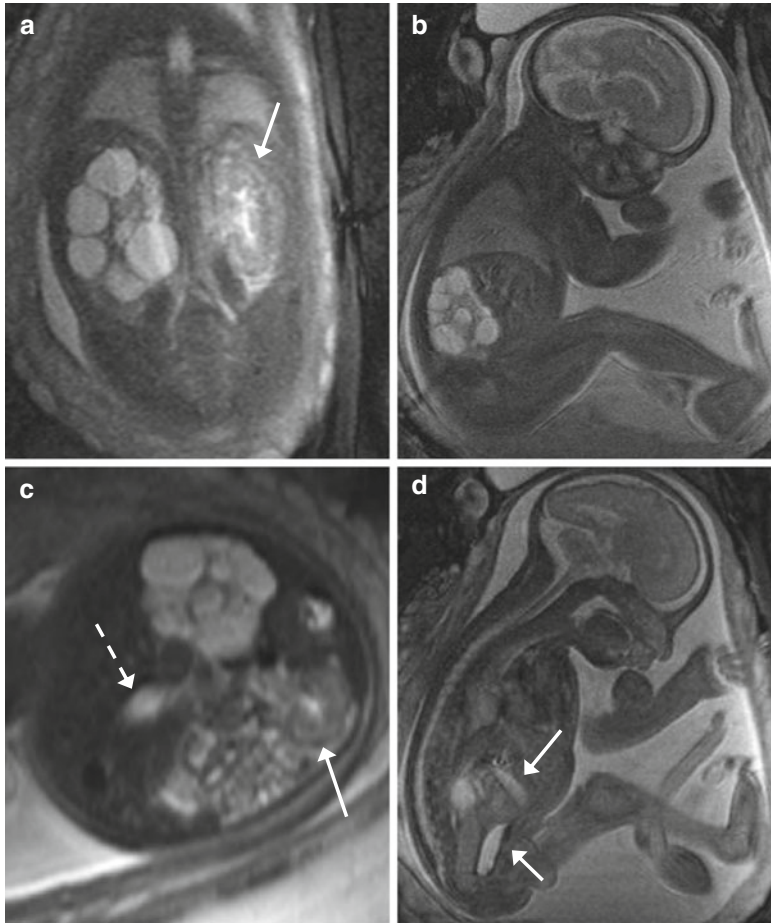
Renal polycystic kidney (GW 27+3). (a–d) Coronal (a), sagittal (b, d), and axial (c) T2-weighted images (TR/TE ∞ /95 ms): the right kidney is increased in volume and completely replaced by multiple
